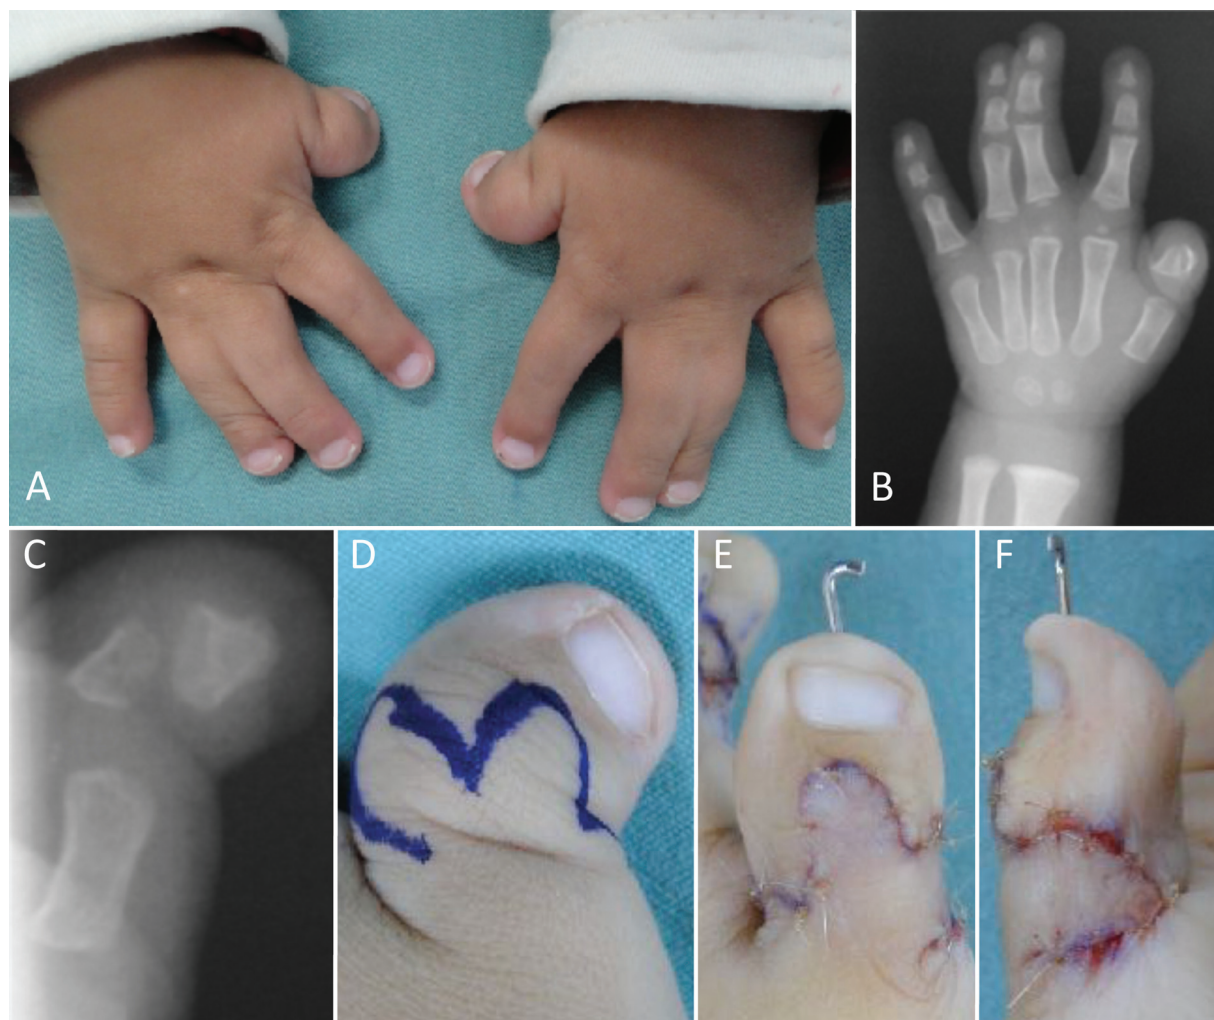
Patient with Pfeiffer syndrome presenting bilateral hand changes, with the typical hitchhiker thumb deformity associated with third- and fourth-digit syndactyly (A). Radiograph showing a delta proximal phalanx of the thumb, and hypoplasia of middle phalanges of long fingers (B). Thumb radiograph details clinodactyly and delta phalanx (C). Surgical planning with bilobed skin flap (D). Elevation and rotation of bilobed flap with complete skin cover (E and F).
